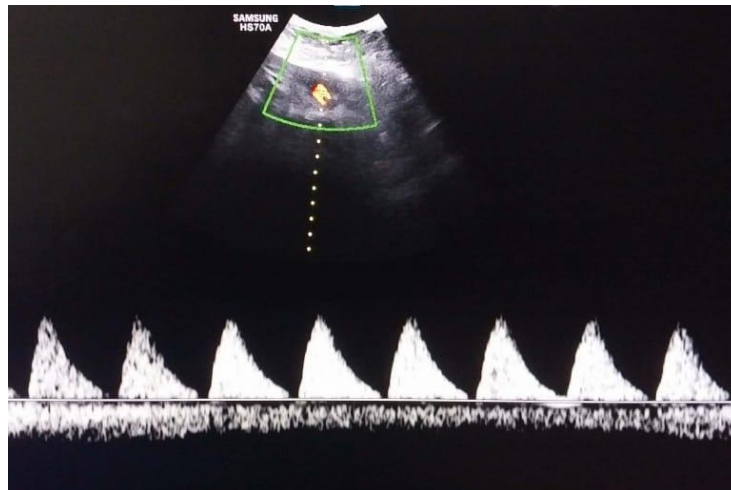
Umbilical artery doppler showing absent end diastolic flow in an IUGR fetus
